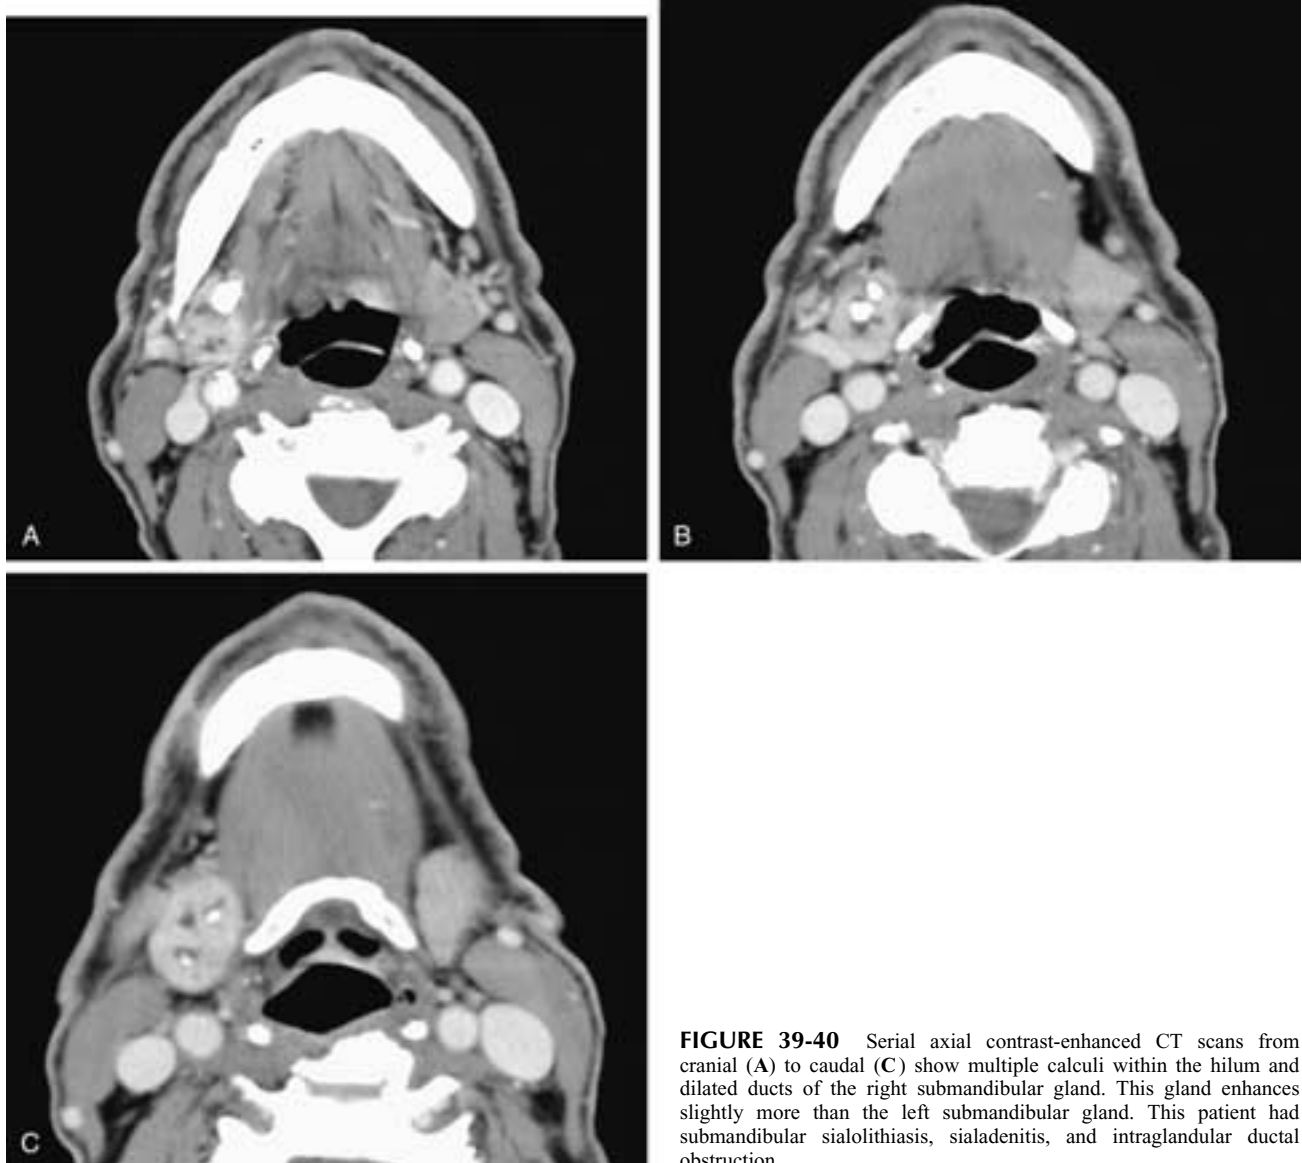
Serial axial contrast-enhanced CT scans from cranial (A) to caudal (C) show multiple calculi within the hilum and dilated ducts of the right submandibular gland. This gland enhances slightly more than the left submandibular gland. This patient had submandibular sialolithiasis, sialadenitis, and intraglandular ductal obstruction.
